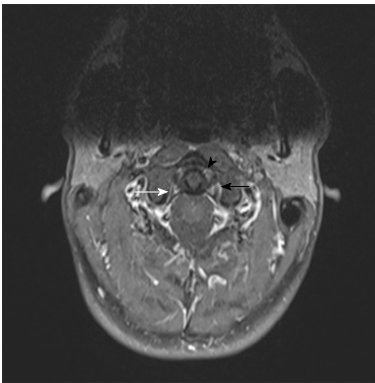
High resolution contrast-enhanced 3T magnetic resonance imaging, fat-saturated gradient echo sequence performed 6 mo following the trauma. In the contrast-enhanced T1w fat-suppressed magnetic resonance imaging sequence note the contrast enhancement in the periligamentous venous plexus (arrow head). On the left side lower than on the right side. No TS symmetry of the joint space left vs right side (black and white arrow).
